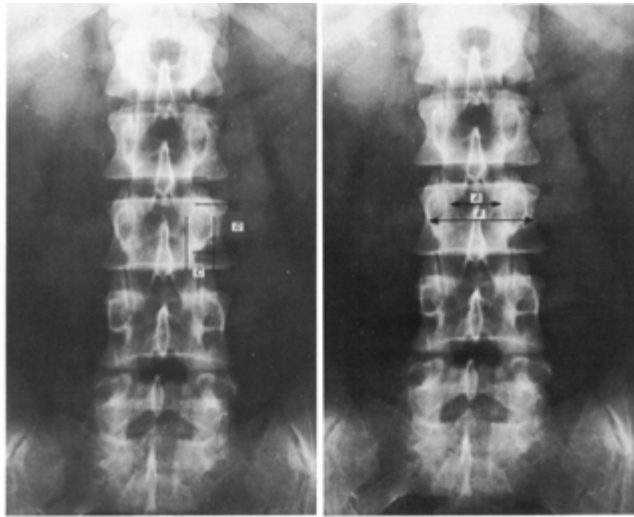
Plain x-ray of lumbar spine antero-posterior view. Left panel: horizontal (C) and vertical (D) diameters of the pedicle. Right panel: interpedicular distance (A) and transverse diameter of the vertebral body (B). After Amonoo-Kuofi (1982).
